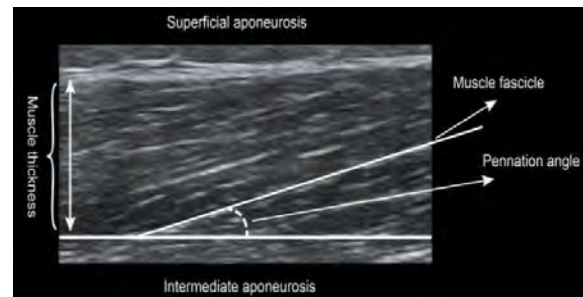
A two-dimensional ultrasound image of the BFlh.
